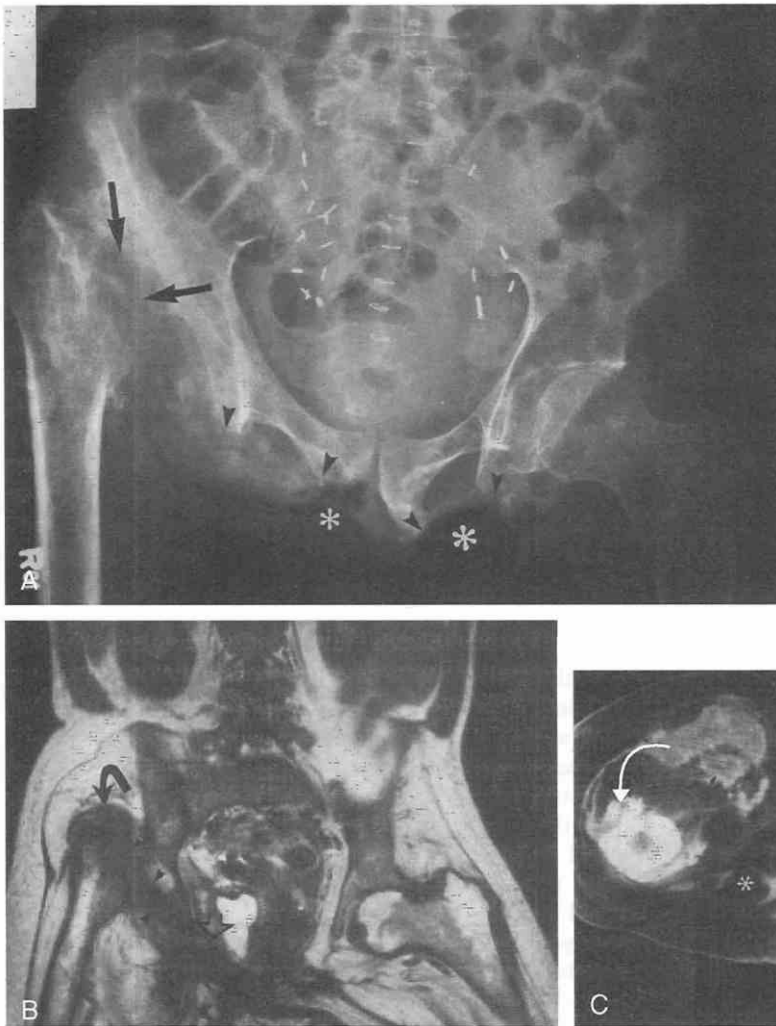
The patient is a paraplegic 35-year-old man with chronic decubitus ulcers and fever. A, Pelvic radiograph shows bone destruction and production about the ischial tuberosities (*large arrowheads*) from chronic osteomyelitis and subcutaneous air related to the decubitus ulcers (*asterisks*). There is also chronic destruction of the right femoral head (*large arrows*). B, Coronal T1-weighted MR image reveals sinus tract (*small arrowheads*) extending from the ischial area of osteomyelitis (*open arrow*) that seeded the right hip joint, resulting in an additional site of pyarthrosis and osteomyelitis (*curved arrow*). C, CT scan shows bone destruction about the right hip (*curved arrow*). A large fluid collection anteriorly represents abscess (*small arrows*) and subcutaneous air (*asterisk*).
